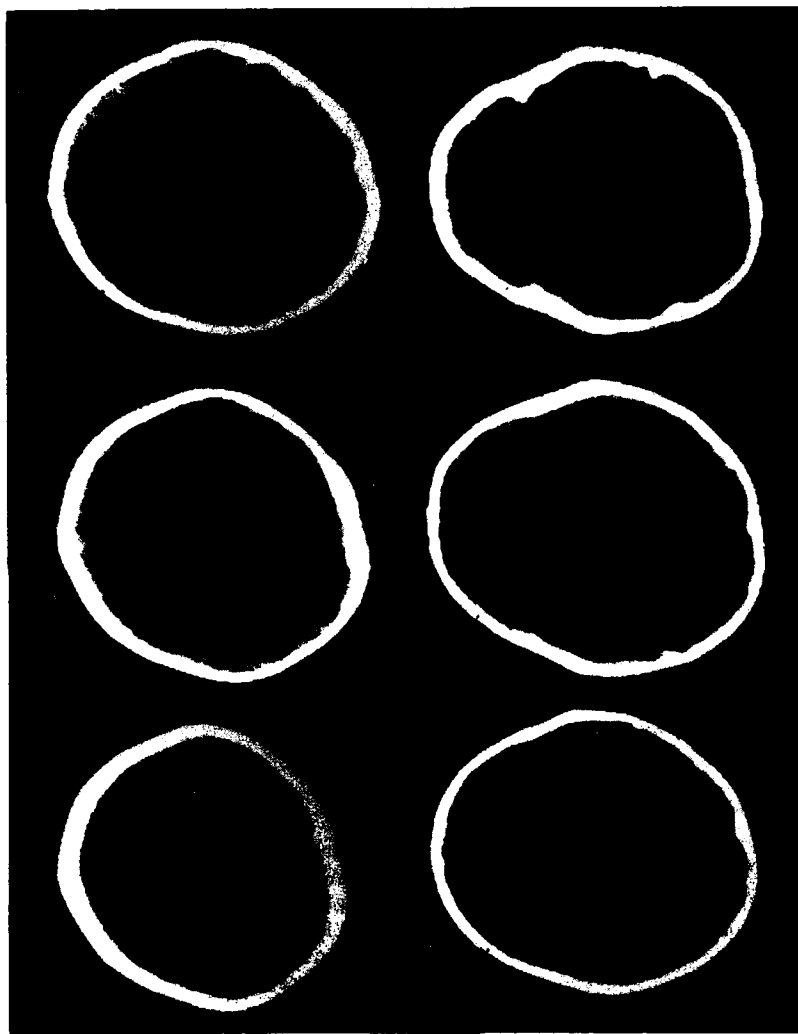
Brain CT scan of congenitally deaf child who still cannot walk at the age of four years. No abnormal neurological signs have been noted, except disequilibrium and hypotonus of legs. Remarkable dilation of the lateral and third ventricles is apparent.
